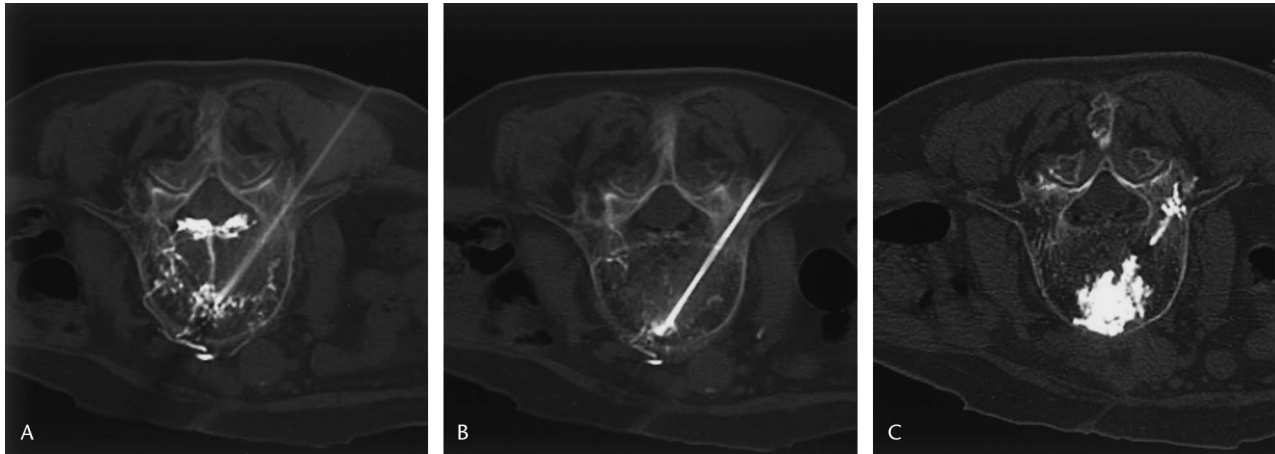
A, CT is performed for imaging of dynamics and immediately after administration of contrast. The internal vertebral venous plexus was visualized via a basivertebral vein, a dangerous anastomosis. B, CT after embolization. The internal vertebral venous plexus was not seen. C, Postoperative CT. The bone cement was almost homogeneously distributed in the vertebrae.
